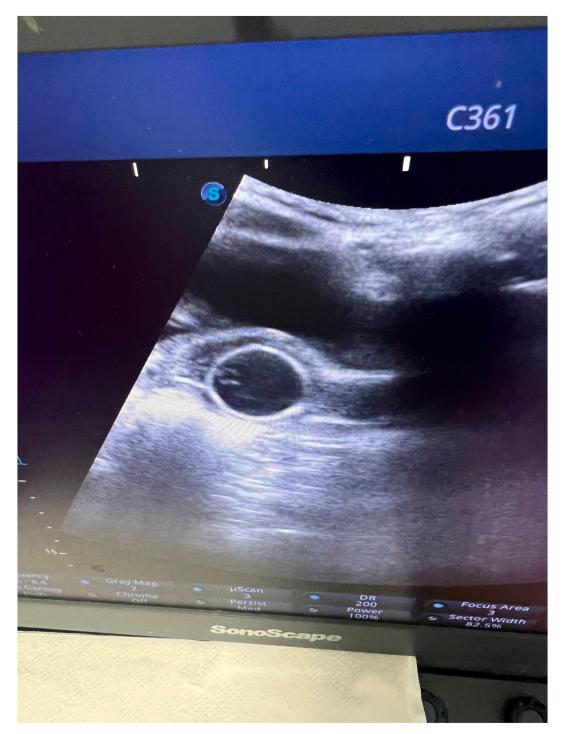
Ultrasonography showing Foley catheter in the uterus 3 months after surgery.
